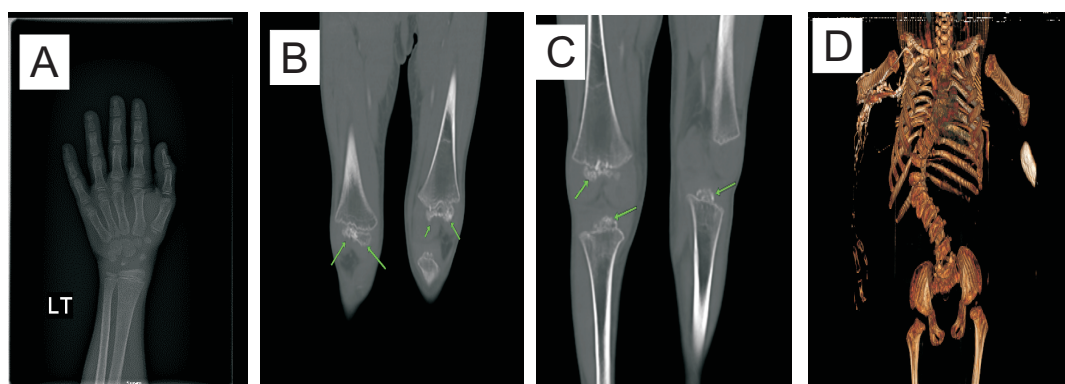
shows the skeletal manifestations in the patient. A) X-ray of the left hand and wrist showing bone age consistent with 8 years of age, B and C) CT images showing heterogeneous epiphysis with irregular ossification. D) showing reconstruction images demonstrating severe thoracic kyphoscoliosis apexed at the T12/L1 level.
